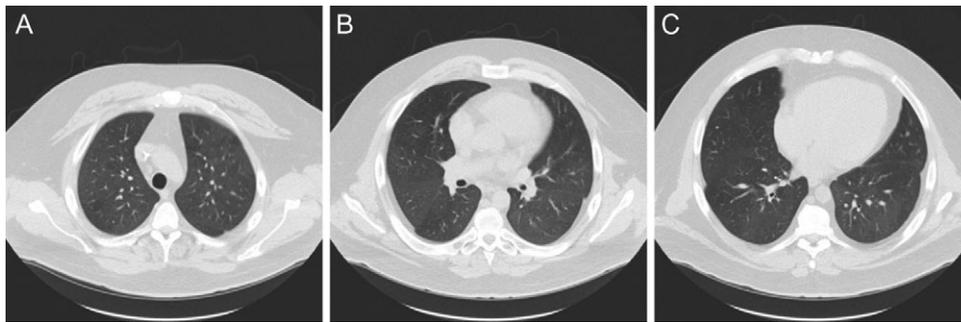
High-resolution chest computed tomography on hospital Day 5 displaying (A) the apices of the lungs, (B) the mid lung zones and (C) the lung bases demonstrating dramatic and rapid improvement of the ground-glass opacities after 5 days of treatment with high-dose glucocorticoids and plasma exchange.
